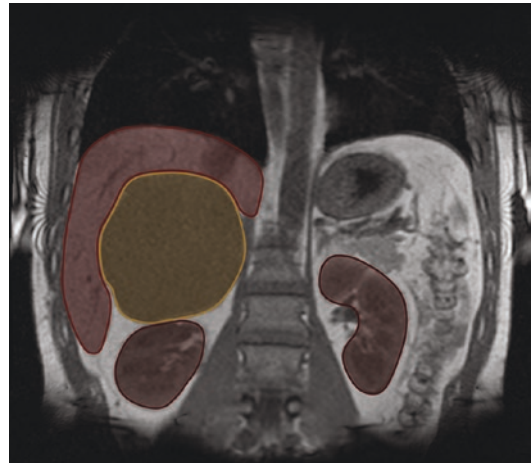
MRI—coronal plane. The giant cyst of the right adrenal (yellow) is pushing the right kidney (dark brown) down. The liver (light brown) is also pushed and compressed by the huge lesion
